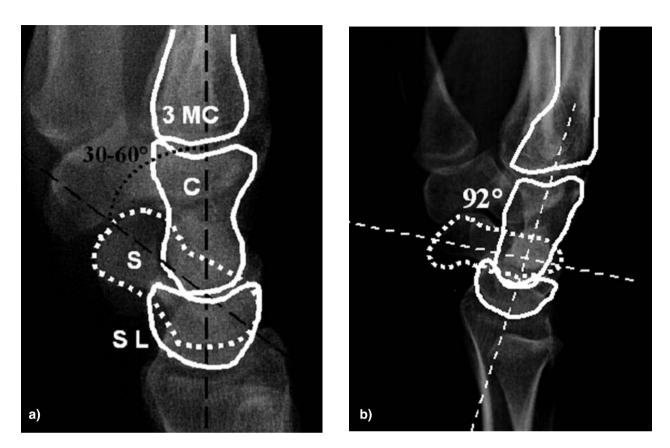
X-ray lateral view; lateral view: radius (R), lunate (SL), capitate (C). a) The normal size of the scapholunate angle is between  $30^{\circ}-60^{\circ}$ . This angle is determined by the intersection of two lines drawn along the major axis of the scaphoid and lunate, respectively. b) An increase in the scapholunate angle to >  $60^{\circ}$  is consistent with DISI
